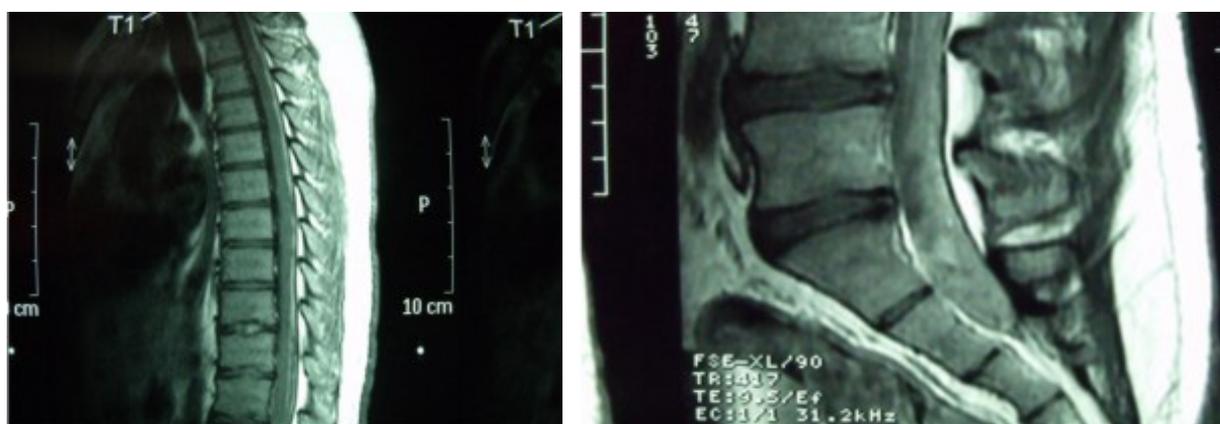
MRI images demonstrating the presence of anomalous intradural and extra-medullary material in thoracic spinal cord and cauda equina.
